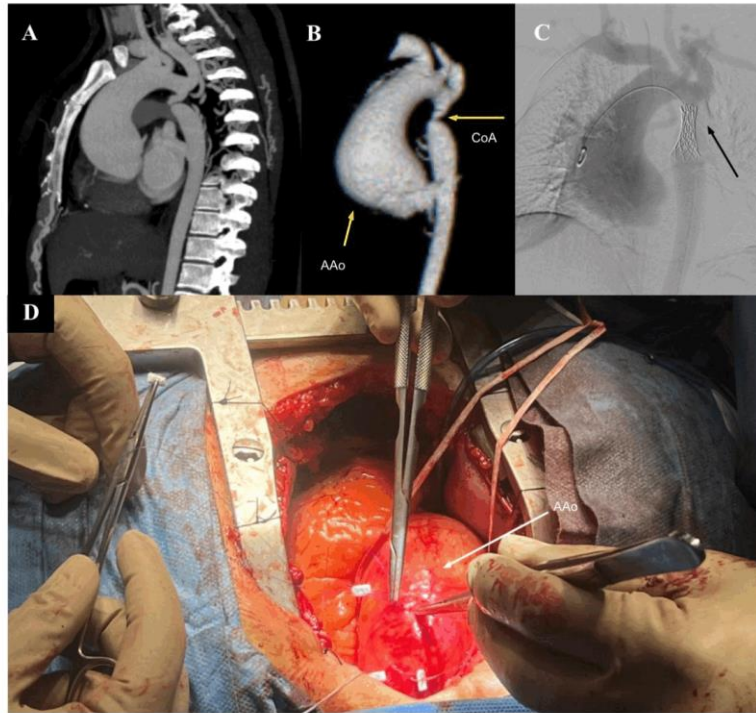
This case highlights the diagnosis and management of aortic coarctation (CoA) associated with an ascending aortic aneurysm (AAo). (A) CT angiography reveals a dilated AAo and severe narrowing distal to the left subclavian artery. (B) 3D reconstruction provides spatial orientation of the defect. (C) Fluoroscopic LAO view shows successful deployment of an endovascular stent in the descending aorta. (D) Intraoperative image demonstrates open surgical repair of the Aao.
